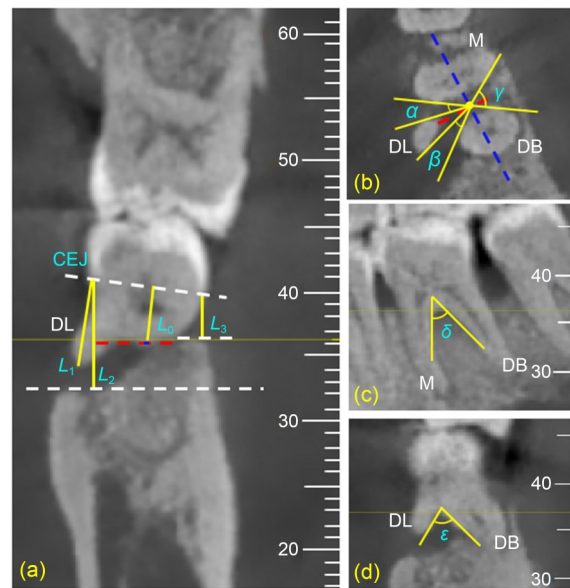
Morphologic features of the distolingual root (DLR) in cone beam computed tomography (CBCT). (a) Length of root trunk (opening of furcation from CEJ) (L_0), length of DLR (measured from CEJ to bottom of apex) (L_1), and depths of lingual and buccal bone defects (measured from CEJ to bottom of defect at the lingual and buccal sites) (L_2 and L_3). (b) Angle of separation between DL and M roots in the transverse section (α), angle of separation between DL and DB roots in the transverse section (β), and angle of separation between DB and M roots in the transverse section (γ). (c) Angle of separation between DB and M roots in the coronal section (δ). (d) Angle of separation between DL and DB roots in the sagittal section (ϵ). The scale sizes shown in figures are in mm. DL: distolingual; DB: distobuccal; M: mesial; CEJ: enamel-cemental junction.
